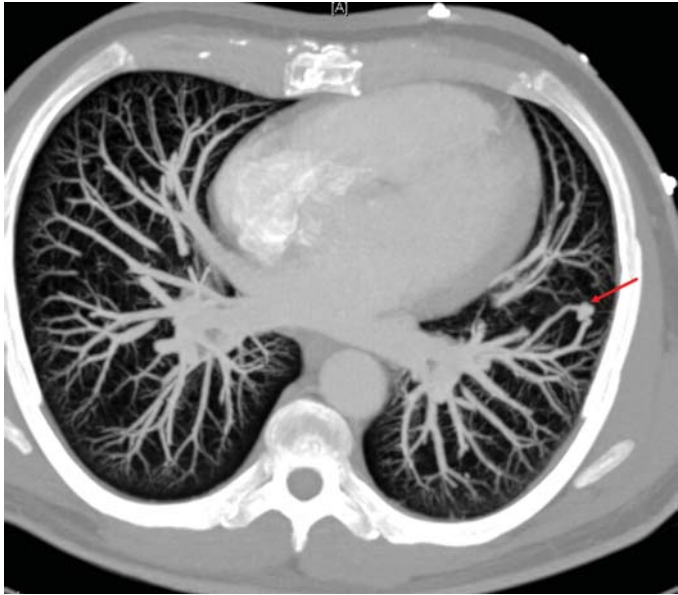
FIGURE e24-47 Pulmonary arteriovenous malformation (AVM) demonstrated on reformatted CT angiogram (red arrow).
